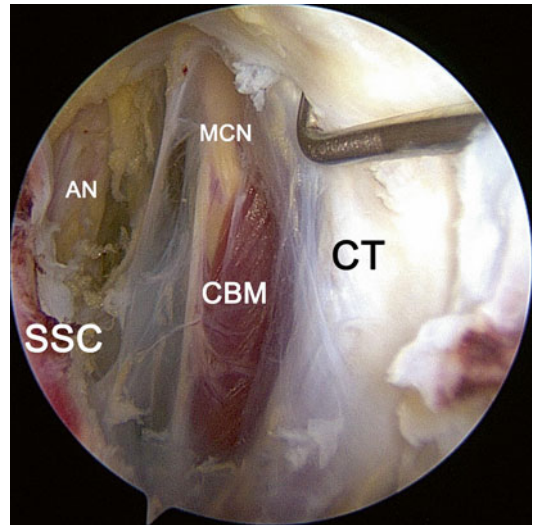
Axillary nerve (AN) and musculocutaneous nerve (MN) entering the coracobrachialis muscle seen through the anterolateral portal. The hook inserted through the anterior portal. CT conjoined tendon, SSC subscapularis muscle
